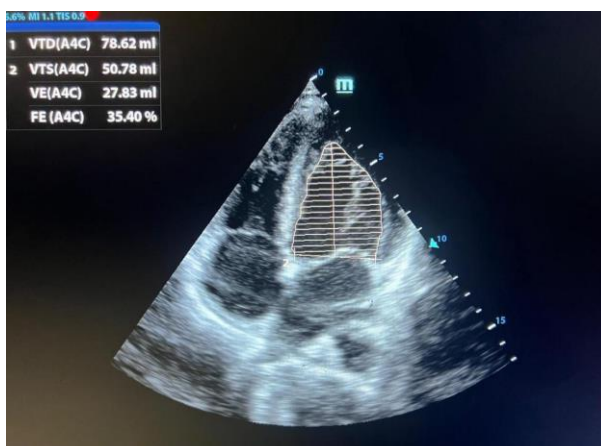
Initial transthoracic echocardiography showing a left ventricular ejection fraction[LVEF] of 35%
